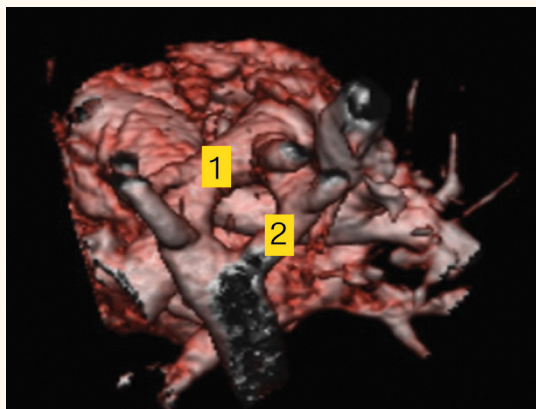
Three-dimensional volume-rendered computed tomography chest angiography image of the third case, showing a double aortic arch (marked 1 and 2).
